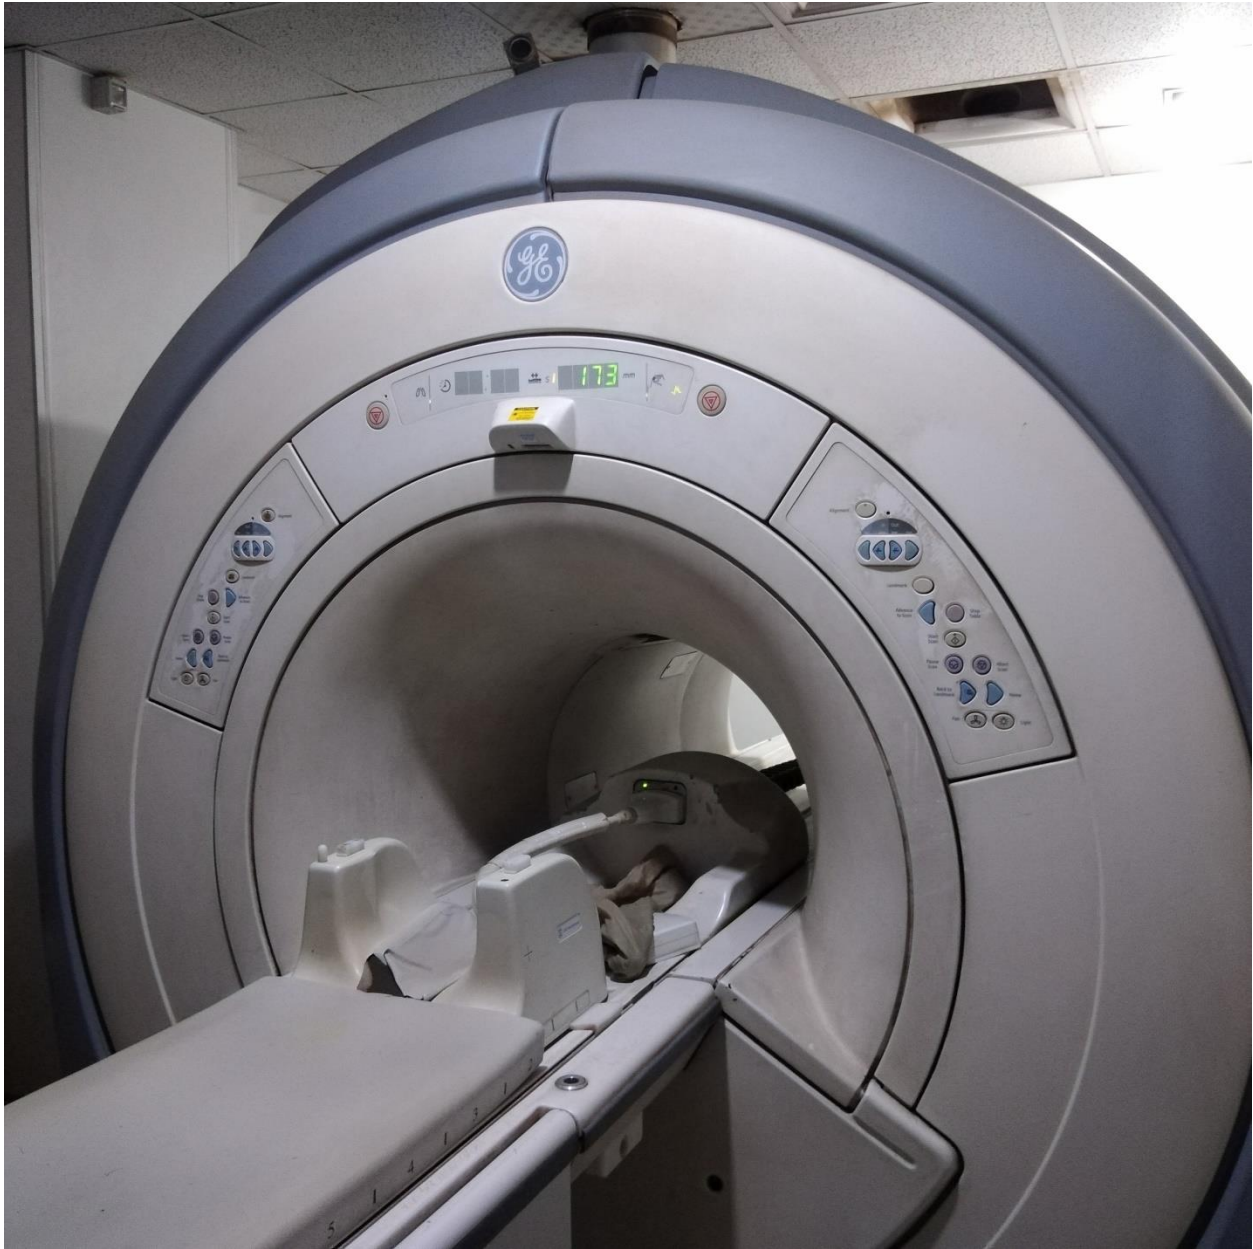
shows a picture of MRI machine, 1.5 Tesla (General Electric) of ANTALIA MEDICAL CENTER.
